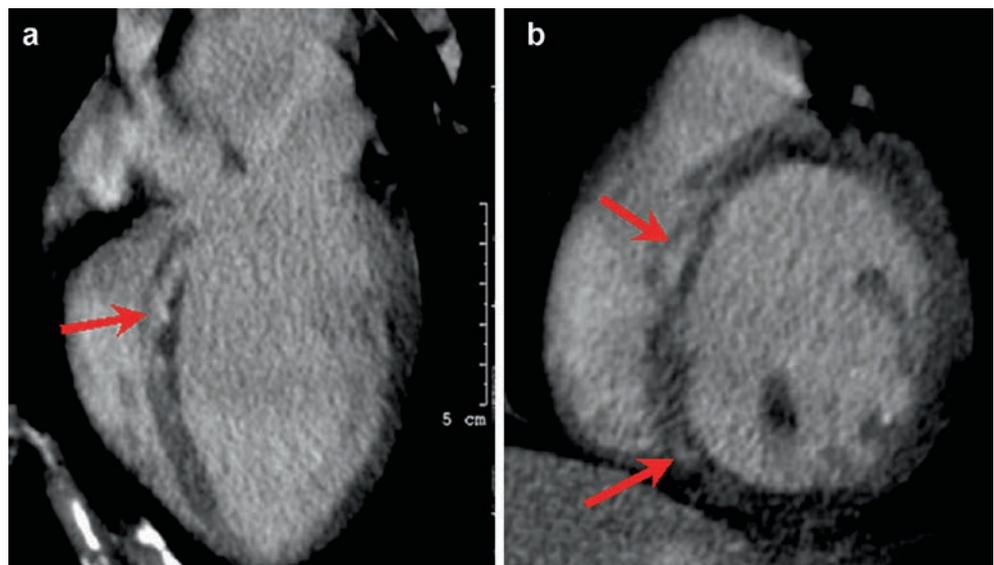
Delayed-enhancement (DE) multi-detector-computed tomography in patient with myocarditis demonstrating intra-mural DE in the septal wall in a long- (a) and short-axis (b) view. Kindly provided by le Polain de Waroux et al.⁷
